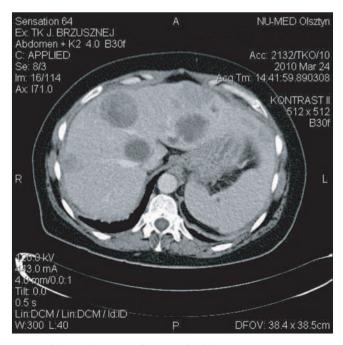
Abdominal CT scan (liver). Multiple hypodensic areas
